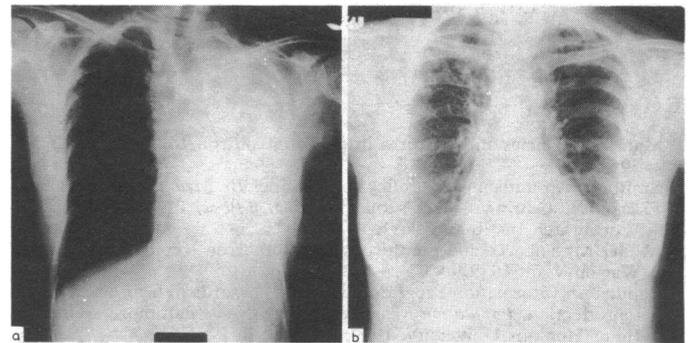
Chest radiographs of the patient in case 1, showing (a) complete collapse of left lung at presentation; (b) re-expansion of left lung after bronchoscopy.
